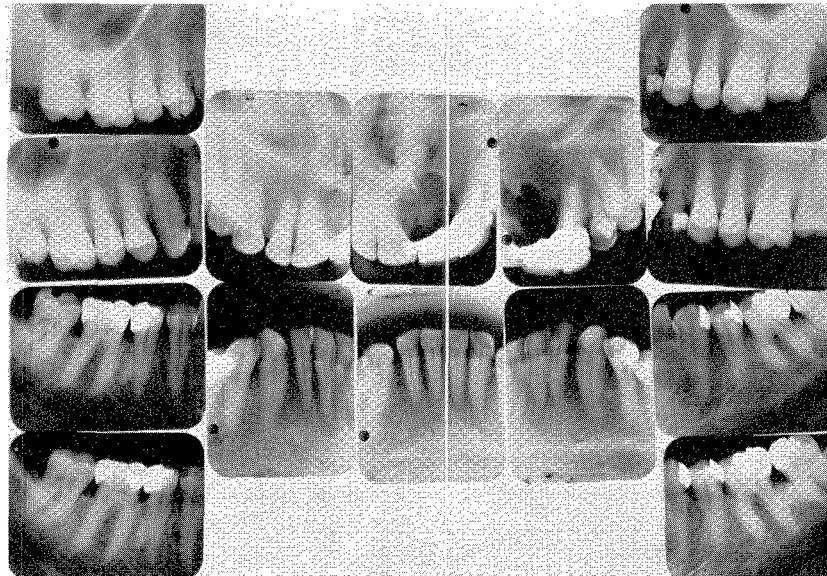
1934 roentgenograms. The anterior bridge stayed in place for over forty years. The anterior cleft may be seen.
